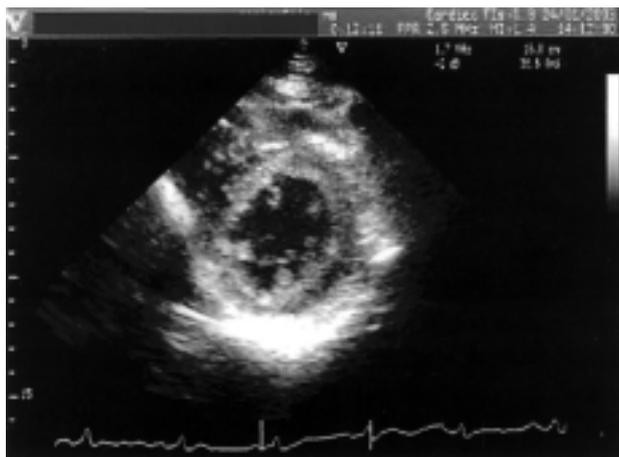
Tissue harmonic two-dimensional echocardiography. A parasternal short-axis view of the left ventricle shows multiple, echo-redundant filaments in the chamber, contiguous with the interventricular septum and the inferior and posterior walls.
